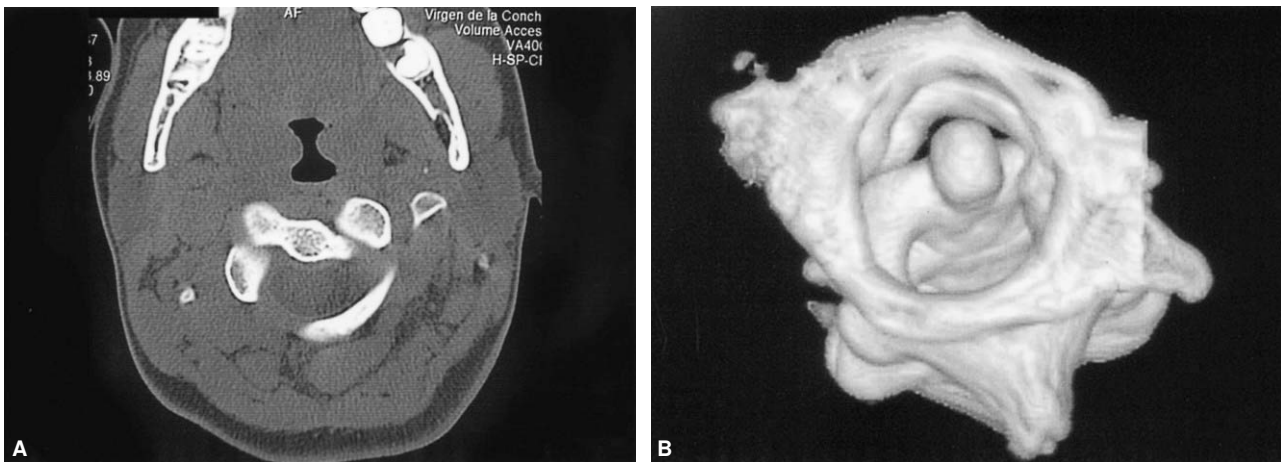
A: Conventional axial CT-scan showing the 32° rotation between C1-C2 in patient N°3. B: three-dimensional reconstruction showing the typical deformity of rotation and C1-C2 impingement.
